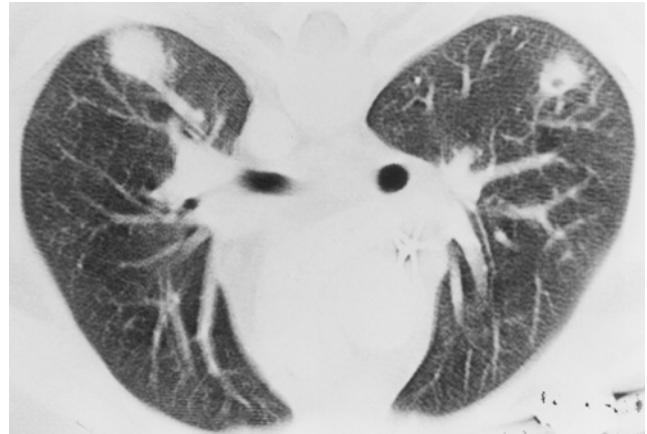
Case 4: A 4-year old boy with polycystic kidney disease who received renal transplant and nine years afterwards developed post-transplant lymphoproliferative disorder. Computed tomography scan shows basal lung nodes
